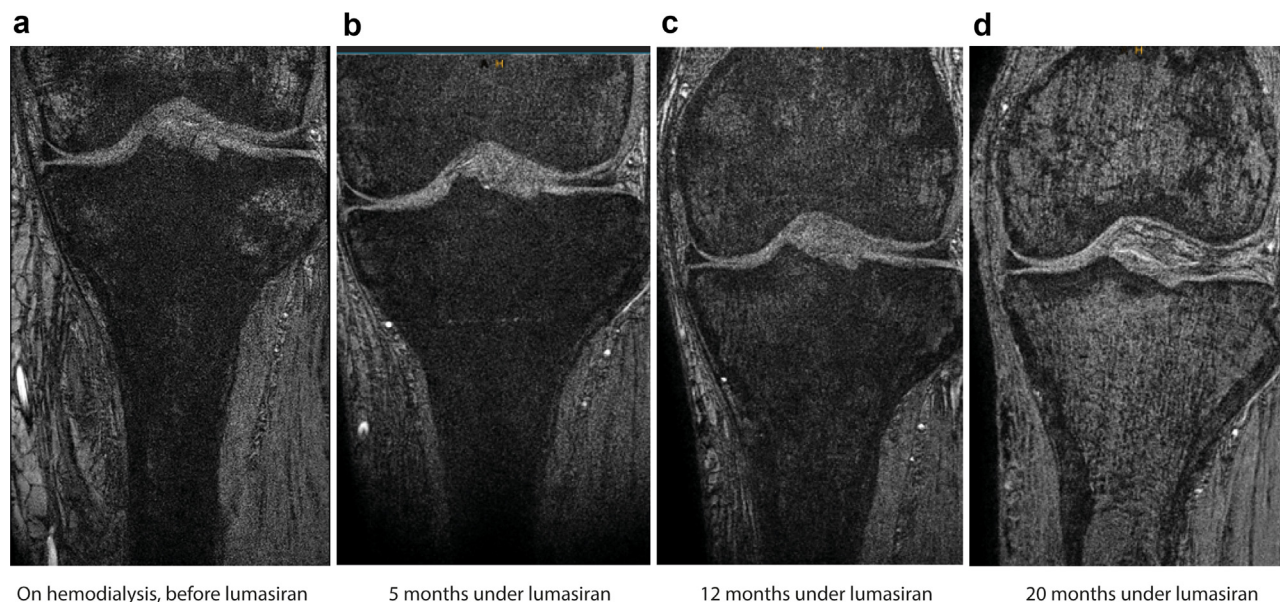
Systemic oxalosis analysis in P23. Bone MRI before starting (a), and after 5 months (b), 12 months (c), and 20 months (d) of lumasiran treatment.
